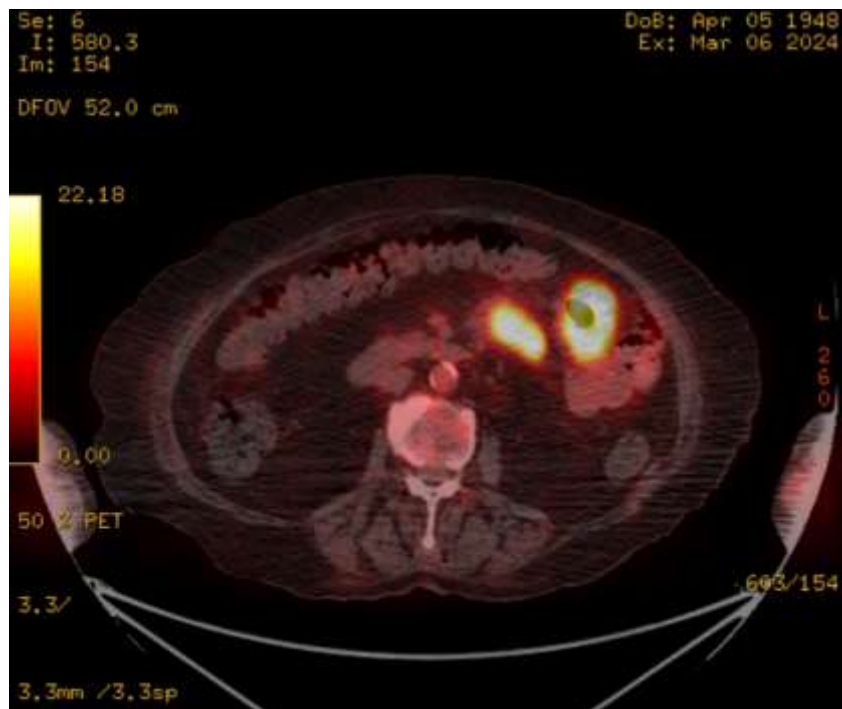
The patient has lymphadenopathies with SUVmax: 21.3 on PET-CT.
